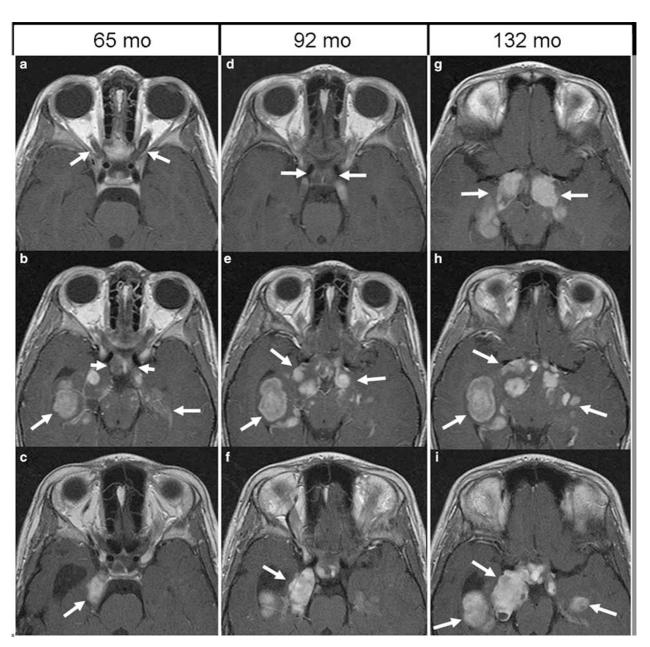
T1-weighted post-contrast axial orbit MR images of patient #7 at 65 months of age (a-c), at 92 months (d-f), and at 132 months (g-i). Early images show enhancing optic pathway glioma involving the chiasm (b, short arrows) and optic radiations (b-c, long arrows). The optic nerves appear free of tumour (a, arrows). The chiasm appears unchanged (d, arrows), but increased growth of the tumour within the optic radiations (e-f, arrows) is noted in the 92 month study. The patient was treated with a second course of chemotherapy. The final images at 132 months of age show no further increase in the extent of the glioma (g-i, arrows).
